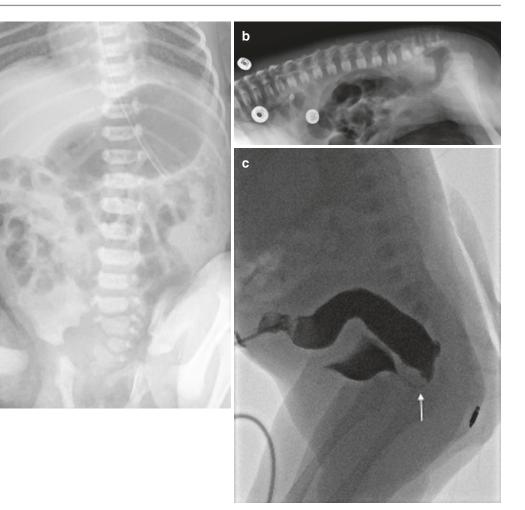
Imperforate anus. Plain film (a) demonstrates gas filled bowel loops and paucity of gas in the rectum. Dysgenesis of the sacrum is noted. Prone cross table beam lateral radiograph with buttocks up (b) shows air in the non-dependant rectum at the level of obstruction. Selected lateral image from a post-operative water soluble distal
